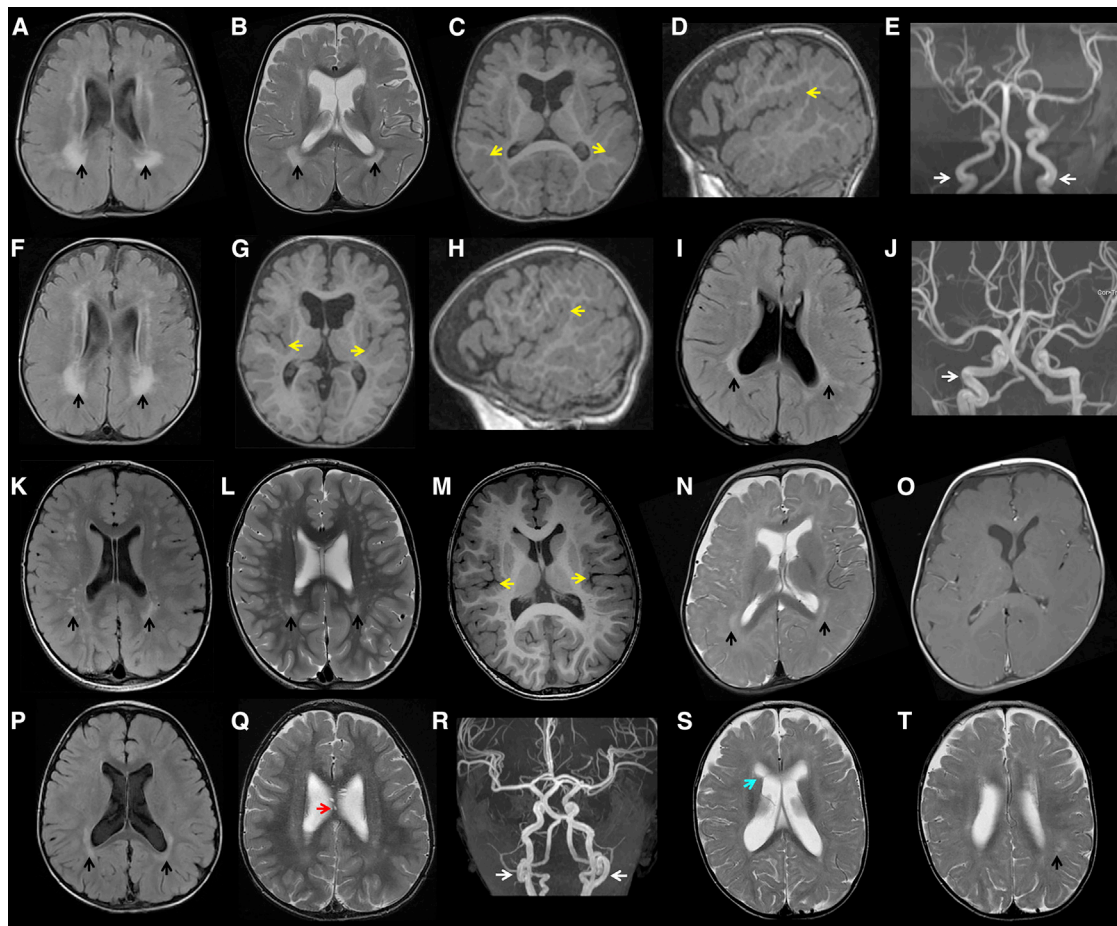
MRI Brain Abnormalities in Individuals with *PCGF2* Mutations
